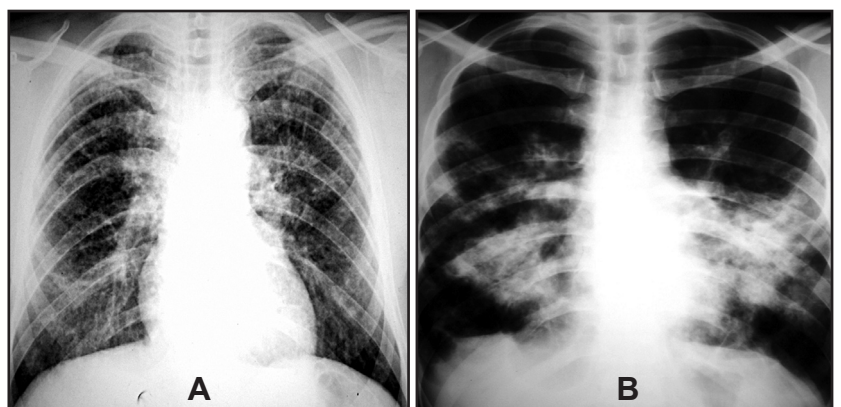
A) Postero-anterior chest x-ray. Case #2, male, 49 year-old: reticular-nodular pattern. B) Postero-anterior chest X-ray. Case #10, male, 36 year-old: lung consolidation pattern.
